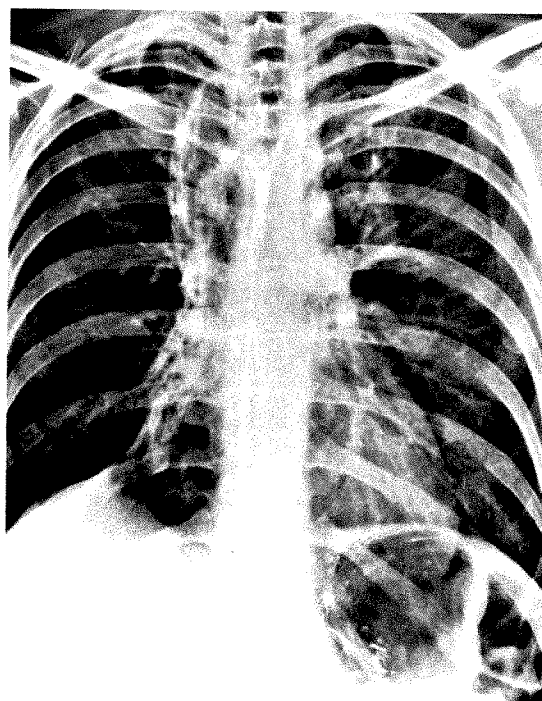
Case II. Chest roentgenogram 6 months after therapy shows moderate mediastinal fibrosis.
